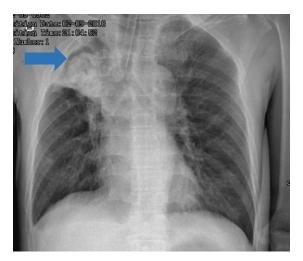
Chest radiograph on current admission with arrow showing an air crescent over an inhomogenous opacity in right upper zone (Monod sign)
